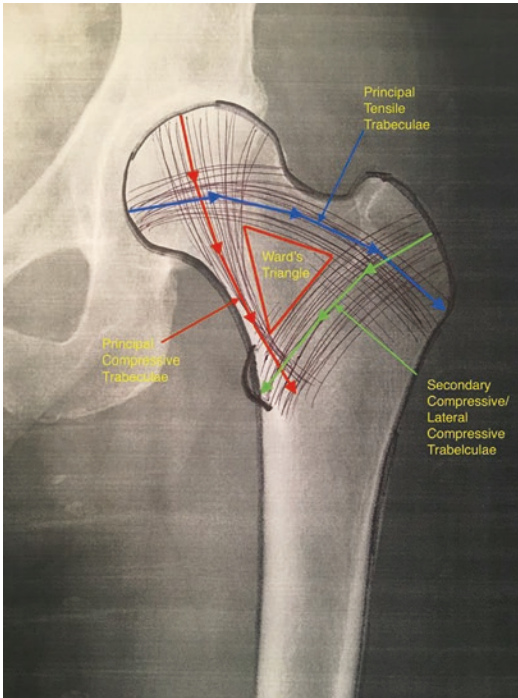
Plain AP radiograph of the left hip demonstrating the principal compression and tension trabeculae of the proximal femur as well as the secondary compressive trabeculae. Note the central aspect of the femoral neck which is devoid of trabeculae called Ward's triangle and which is bounded by the principal tensile and compressive trabeculae and the secondary compression force
